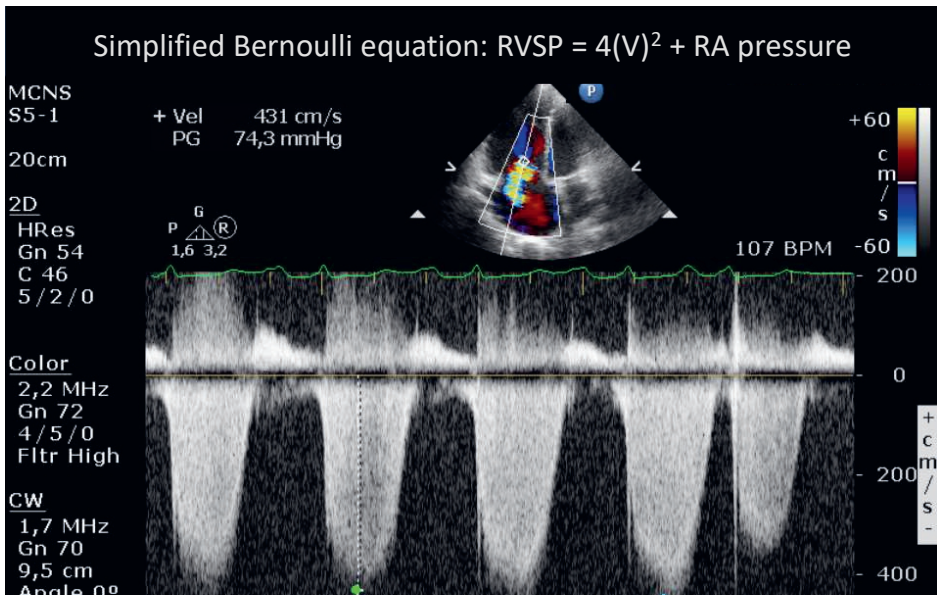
Echocardiographic measurement of the tricuspid regurgitation velocity and calculation of RVSP using the simplified Bernoulli equation.
